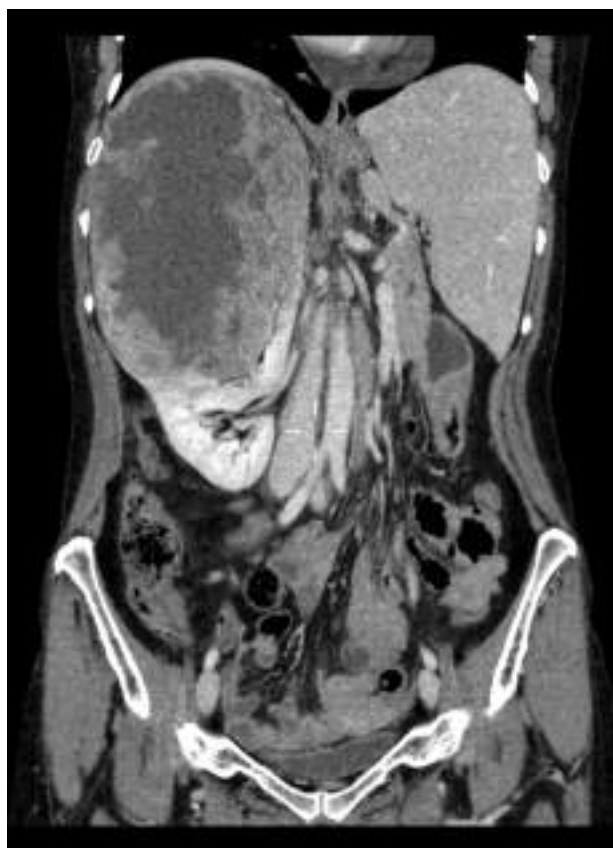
Coronal CT scan of the abdomen – Renal cell carcinoma
